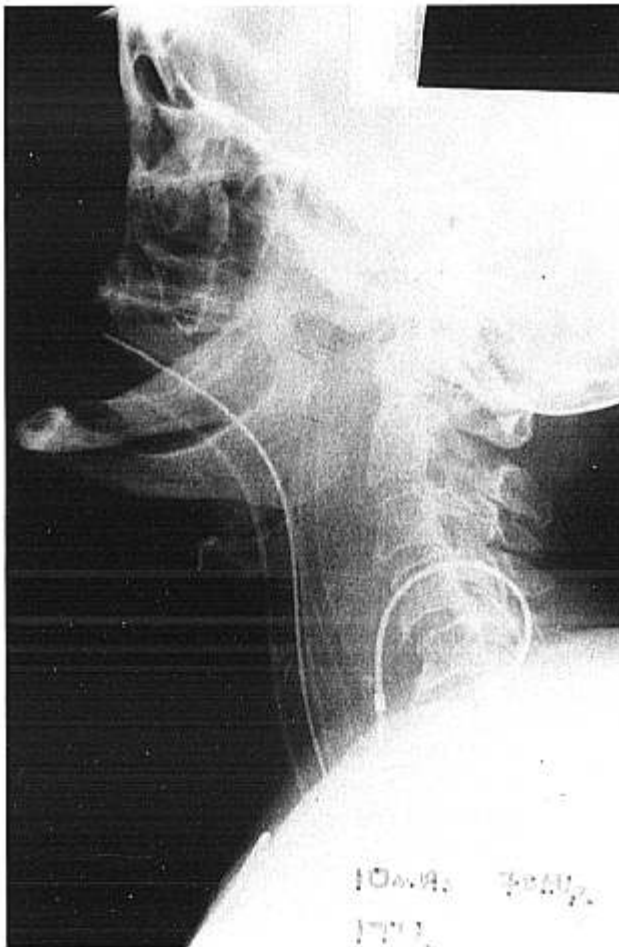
Lateral radiograph of neck showing marked widening of the retropharyngeal space 10 h after the acute hemorrhage.
